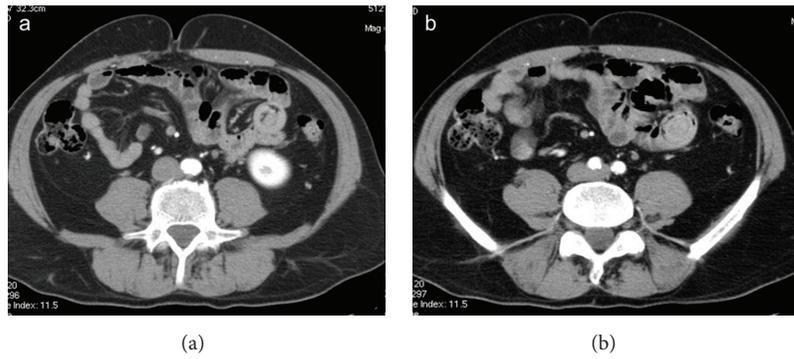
Enteroenteric (ileoileal) transient intussusception in a traumatized patient. Axial CT images oriented perpendicular to the longitudinal plane of the intussusception demonstrate the typical multilayered appearance of small bowel intussusception. Heterogeneous “target” mass with the intussusciptens, intussusceptum, and vessels within the invaginated mesenteric fat. No signs of significant obstruction, only mild stasis in the small bowel.
